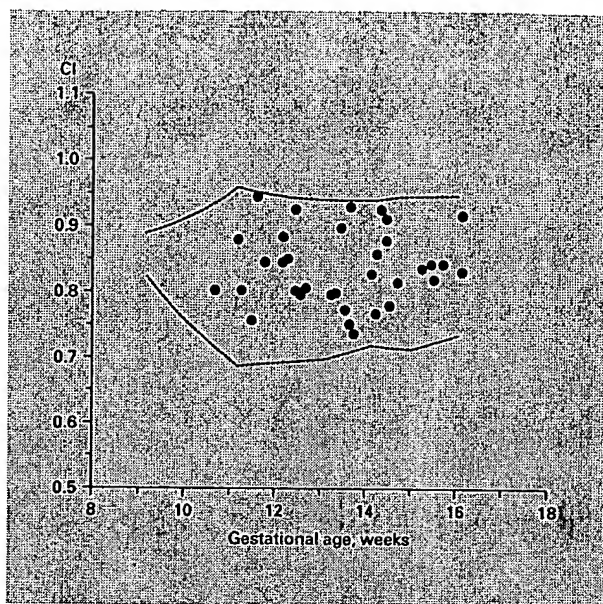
Ultrasonographically based cephalic index (CI) versus gestational age (2.5th and 97.5th percentile). ● = Fetuses with trisomy 21.
